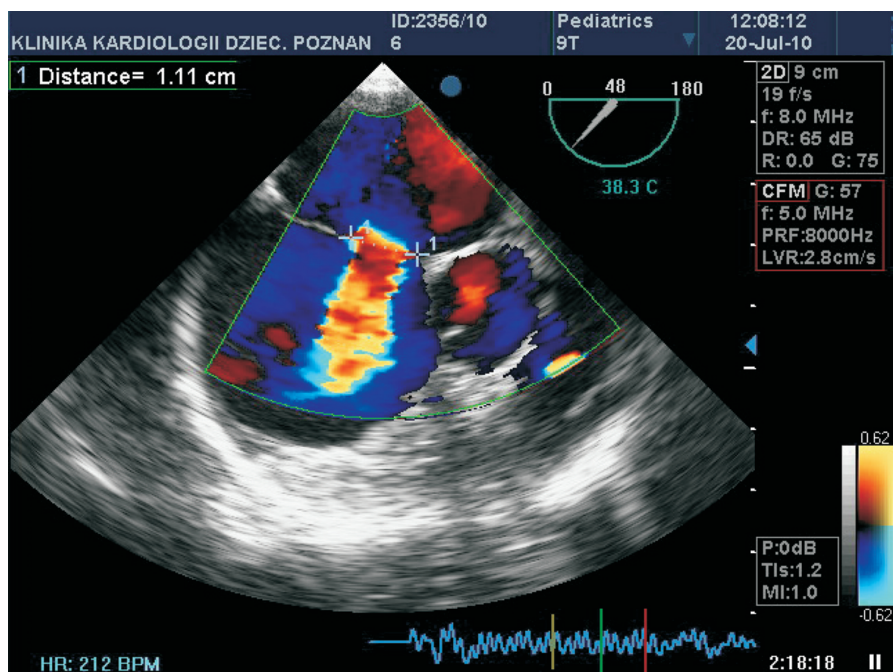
Transoesophageal echocardiography. L-R shunt across the ostium secundum atrial septal defect (ASDII)
